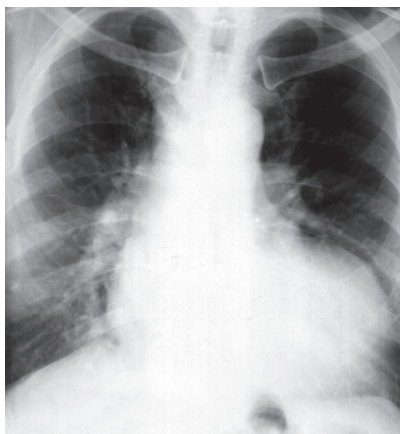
Frontal X-ray. Aortic heart configuration
